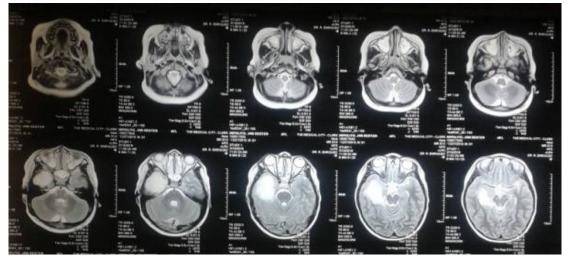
Contrast cranial MRI images of our 5-year old patient showing a non enhancing lesion over the right temporo-parietal area as identified by the red arrows.
